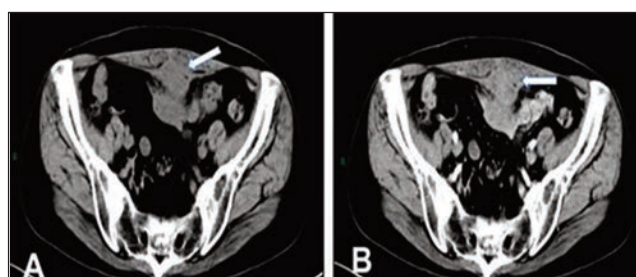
A) CT image of the pelvic shows a soft-tissue space occupying mass (Headed arrow) measuring 44×41 mm (AP x TR) with seemingly connected cord urachal is seen below the anterior abdominal wall, and the mass is not clearly demarcated. Contrast-enhanced scan B) shows that the mass is markedly heterogeneously enhanced. AP, anteroposterior; TR, transverse.
